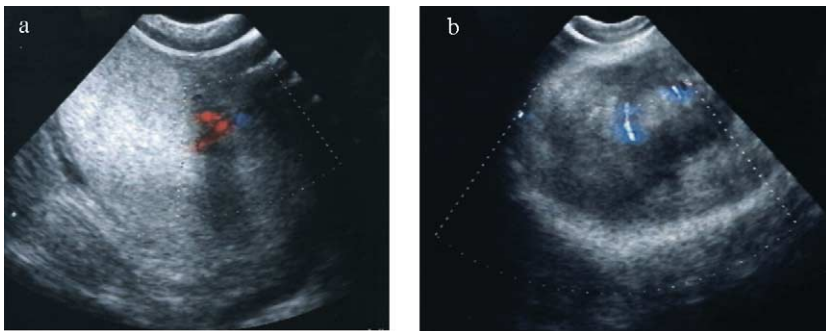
Color Doppler ultrasound images of testicular pathologies: (a) vascular malformation within testicular parenchyma and (b) testicular tumor.
